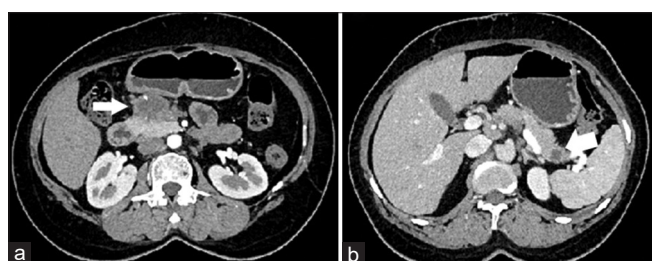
Contrast enhanced computed tomography images of head of pancreas (a) and tail (b), showing irregular hypodense nonenhancing masses with few vessels traversing through the mass in head region (arrows)
